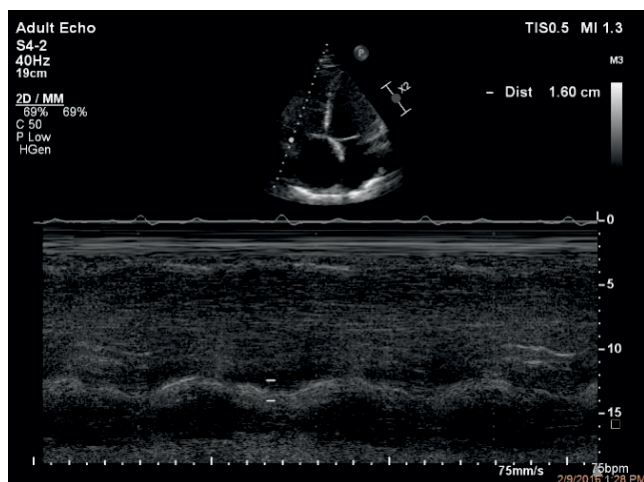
Transthoracic echocardiography, apical view, M mode, TAPSE 16 mm.
